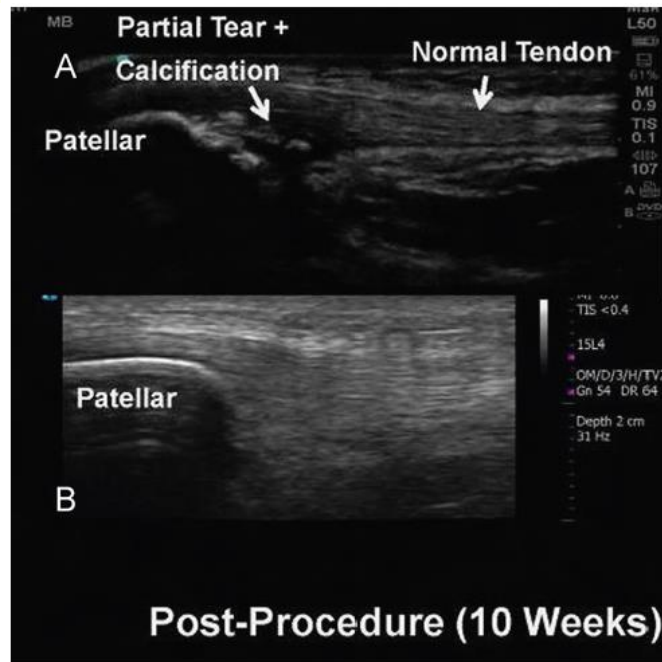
The pretreatment ultrasonic image (A) shown in Figure 2 demonstrates a more normoechoic appearance at 10 months. (B) The symptoms have resolved. (Color version of figure is available online.)
